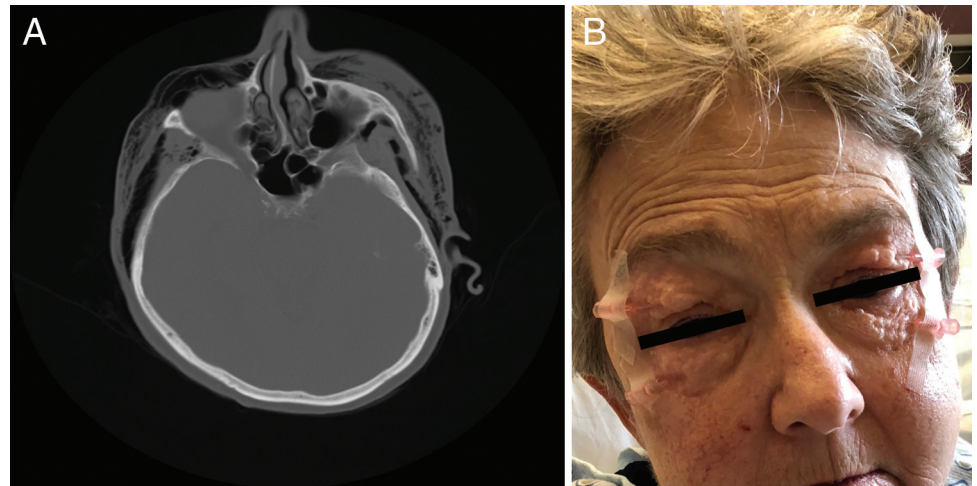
(A) Computed tomography of the head, demonstrating extensive subcutaneous emphysema in the bilateral periorbital regions. (B) Photograph of the patient, demonstrating marked improvement in periorbital swelling after placement of angiocatheters in bilateral eyelids.
